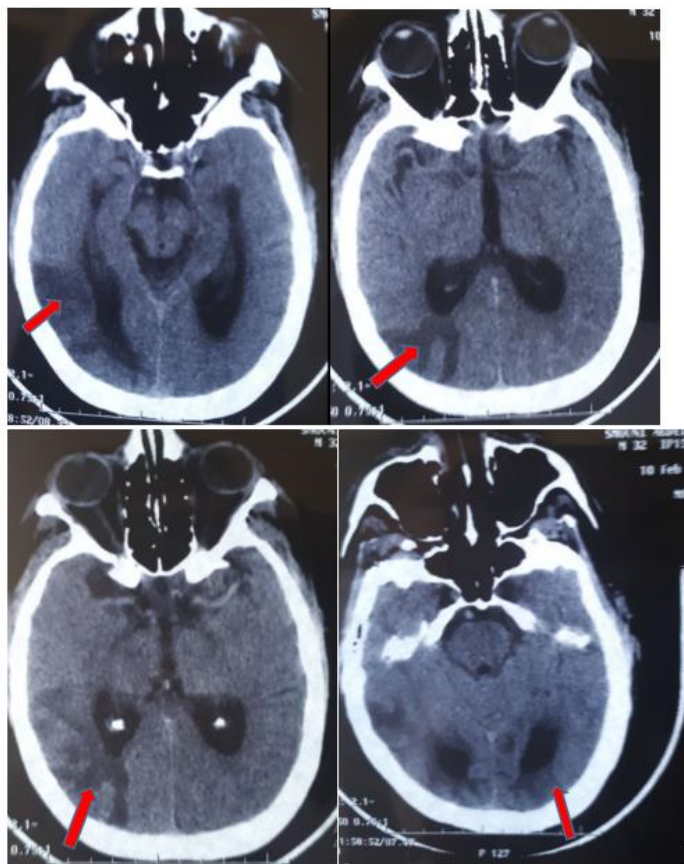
CT scan: showing occipital and parietal hypodensity more marked on the left (red arrow)
